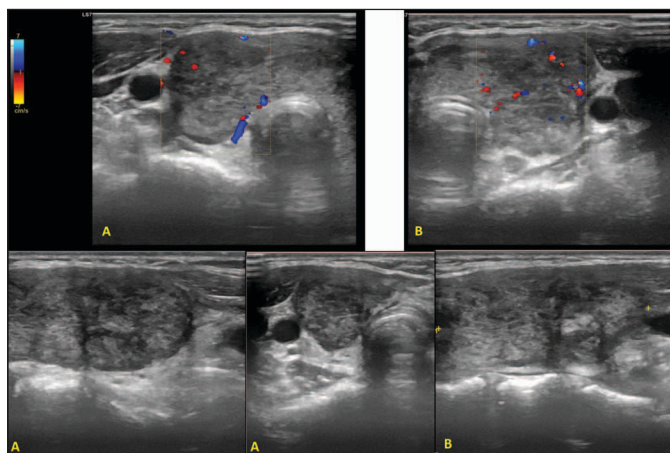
Cervical ultrasonography performed at the emergency department. Diffusely enlarged thyroid gland, with heterogeneous parenchyma and overall decreased vascularization at color Doppler.
